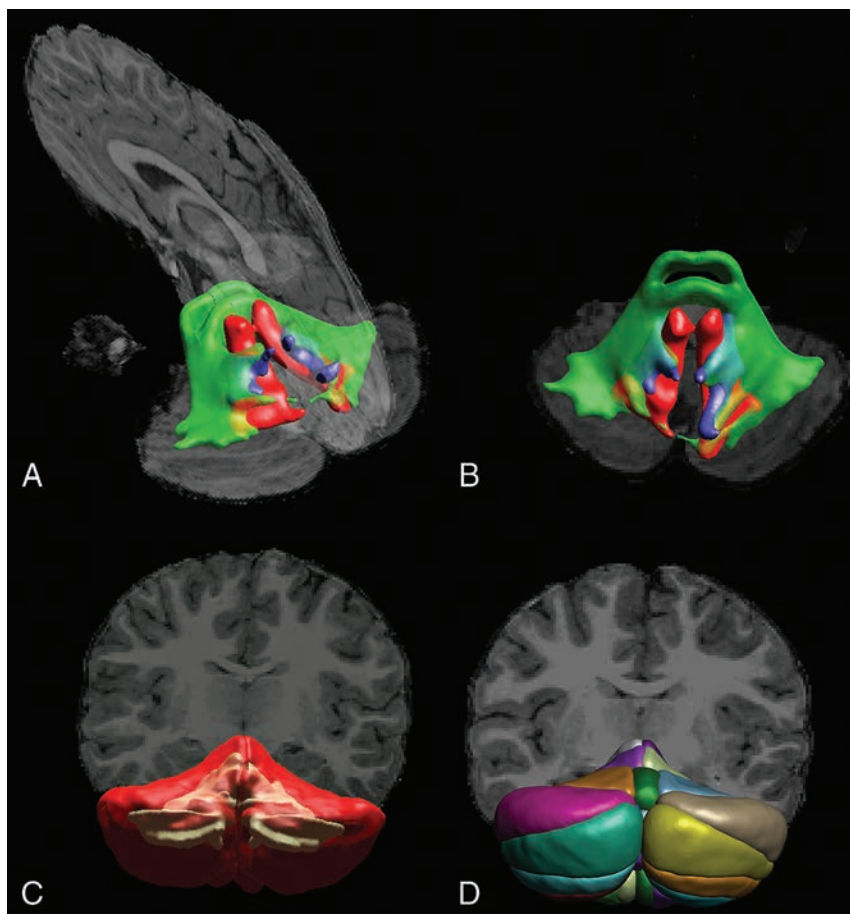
DTI-based tractography of the cerebellar peduncles (A and B) and T1-weighted image segmentation of white and gray matter (C) and cerebellar lobules (D) in a representative subject.
